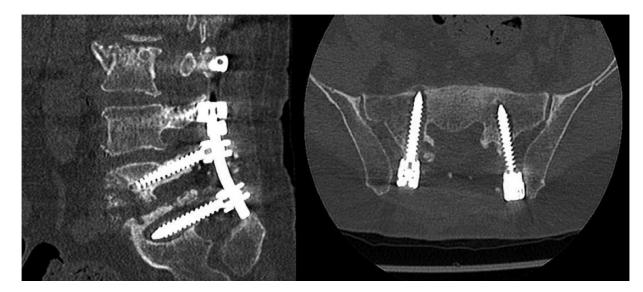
Left sagittal and right axial computed tomography scans showing signs of S1 pedicle screws loosening, mainly on the right side.
